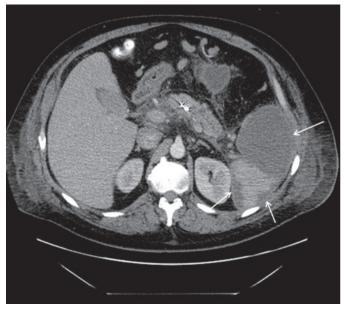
Computed tomography scan of abdomen/pelvis status post coil embolization with several areas of infarction within the spleen (white arrows). Coils within the splenic artery are visualized.
